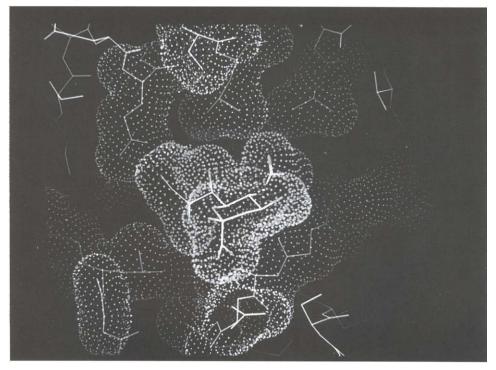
A part of the three-dimentional structure (X-ray structure) of influenza virus haemagglutinin (wild-type) complexed with sialic acid (ref. 8)
